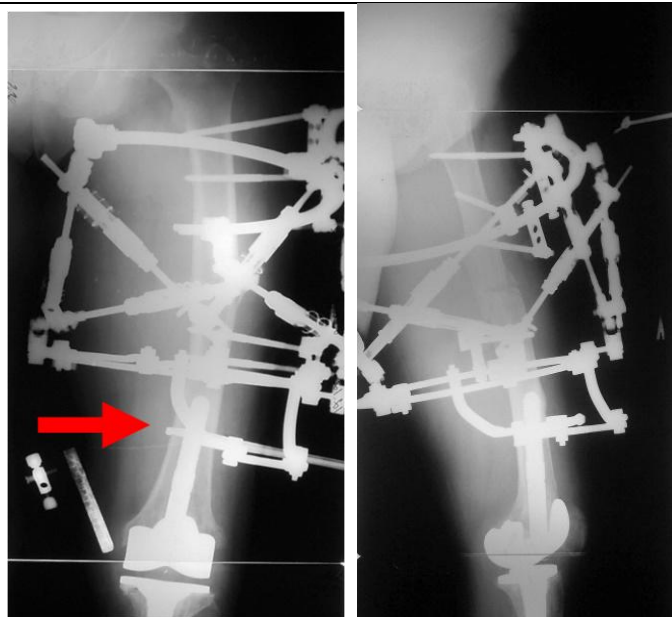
X-rays of patient M., 62 y.o., with periprosthetic deformity of the femur: a – before the surgery; b – deformity correction by Ortho-SUV Frame (SUV-clamps are pointed by arrows)
